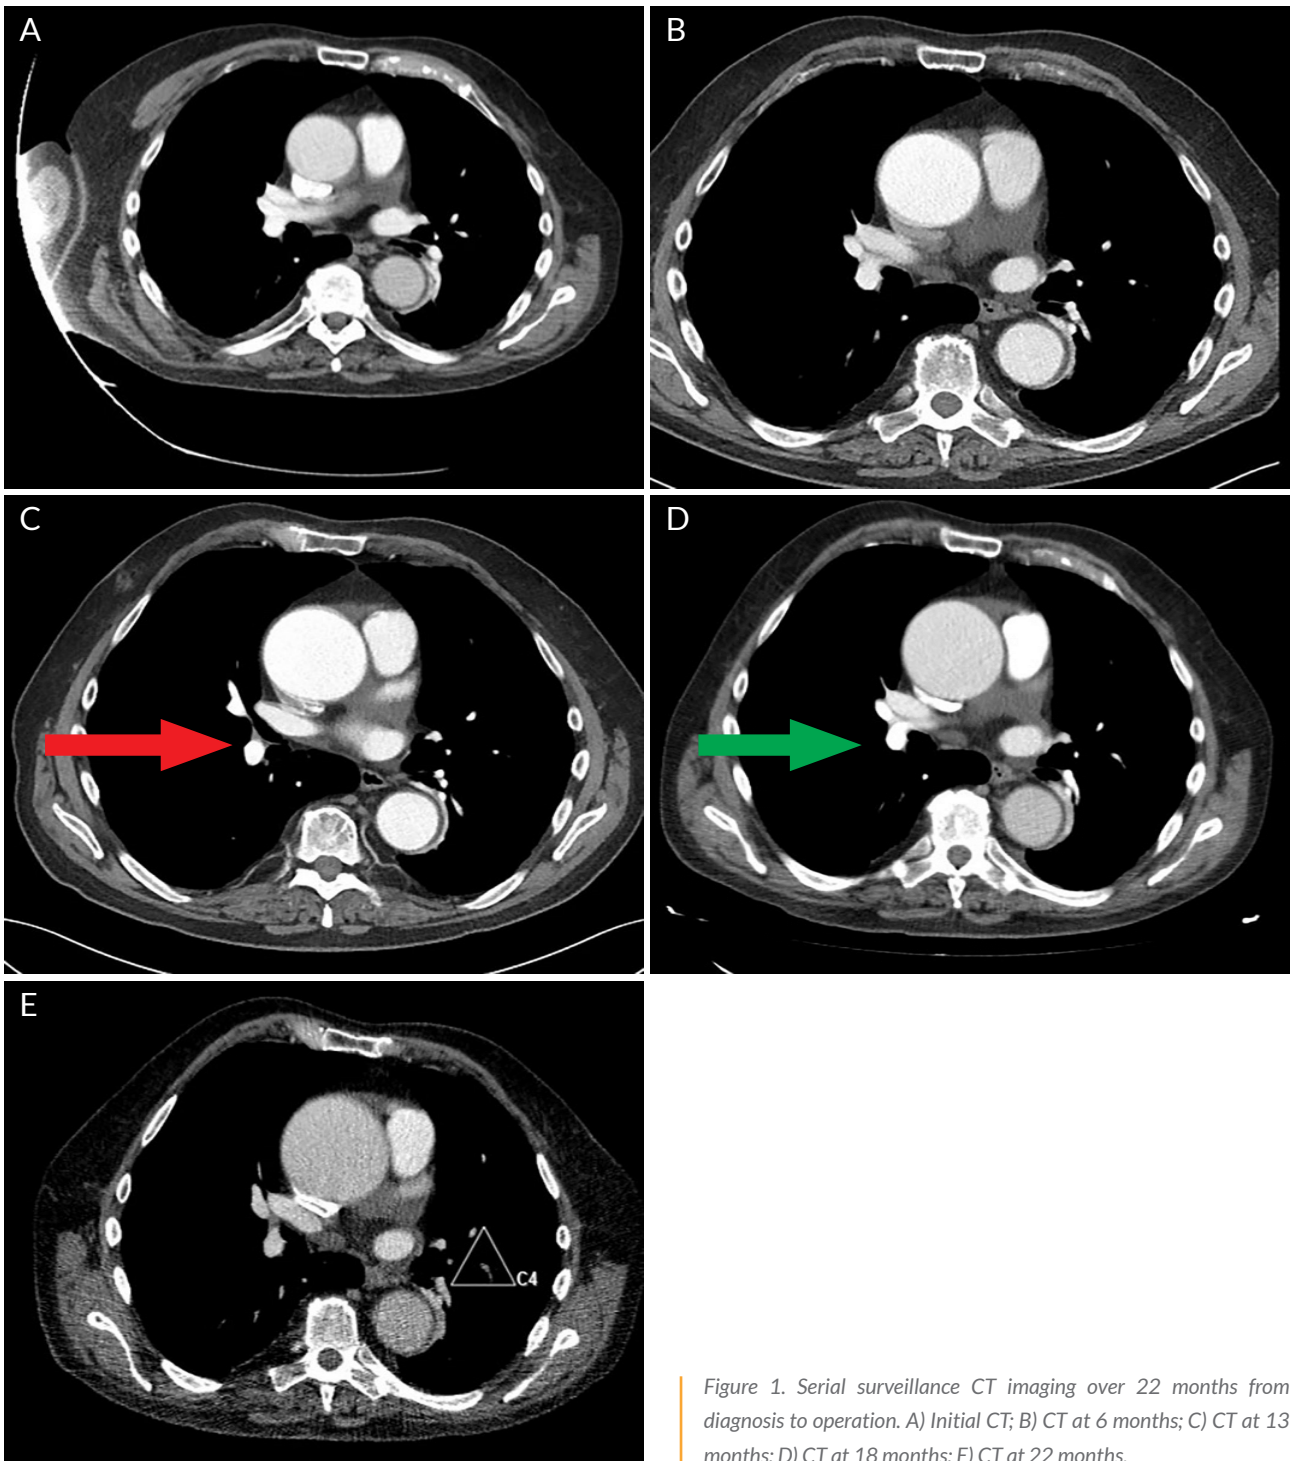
Serial surveillance CT imaging over 22 months from diagnosis to operation. A) Initial CT; B) CT at 6 months; C) CT at 13 months; D) CT at 18 months; E) CT at 22 months.
